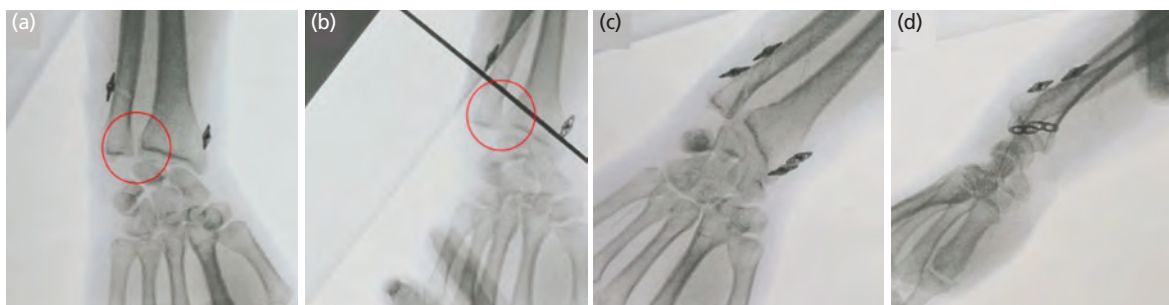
Post-operative radiographic evaluation after the placement of the double suture endobutton fixation. (a, b) AP and oblique fluoroscopic views showing improved alignment of the DRUJ, the gap between the radius and ulna decrease to $\pm 2\text{mm}$. (c, d) Lateral and oblique views confirming proper positioning of the endobutton implants.
